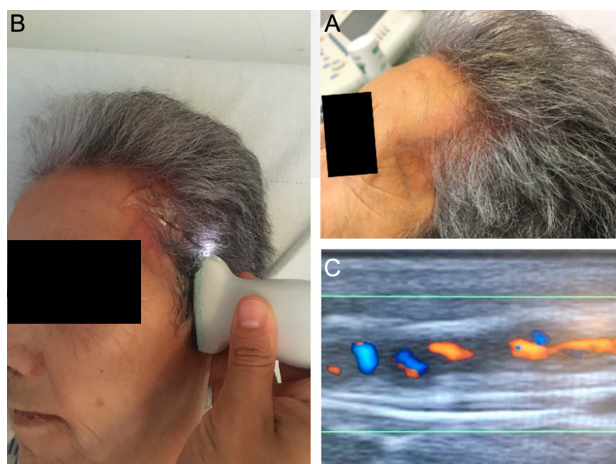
Temporal artery ultrasound exploration. A: The left temporal artery looks thickened and erythematous. B: Probe on longitudinal scan of the parietal branch of the temporal artery. C: Halo sign and stenosis on longitudinal scan.
